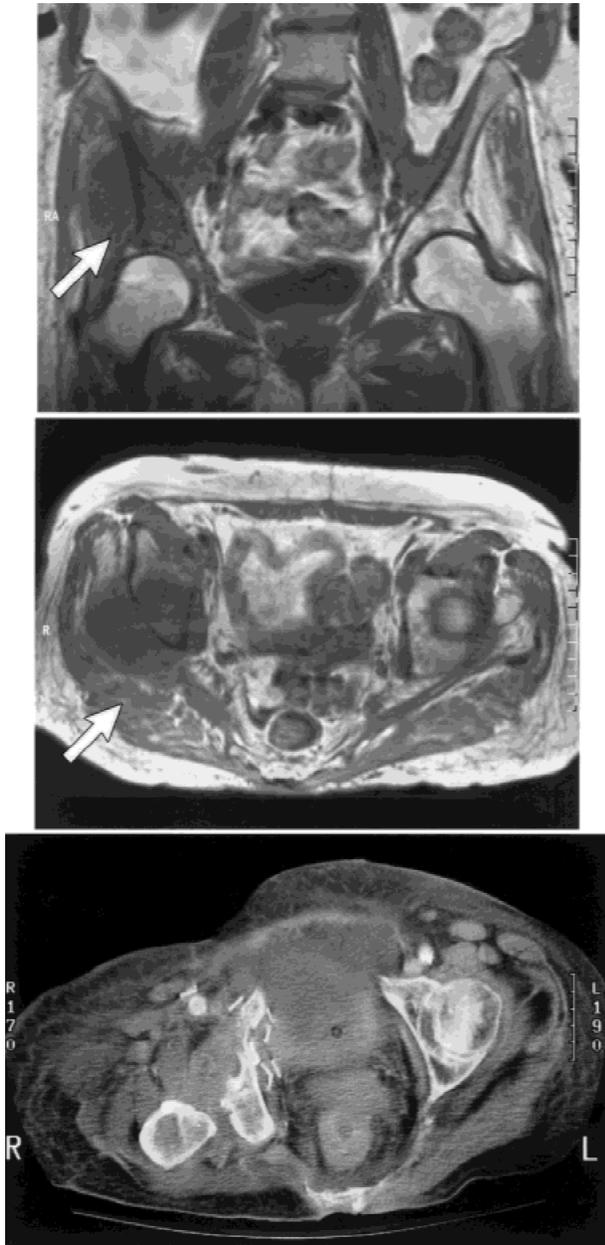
Case Study #2: presurgical magnetic resonance imaging (Figure 2A and 2B) and postsurgical computerized tomography (Figure 2C). Figures 2A (top) and 2B (middle) show a sarcoma arising from the right innominate bone with a soft tissue mass that displaces the gluteus muscles. Figure 2C (bottom) demonstrates evidence of a right hemipelvectomy with extensive edema throughout the soft tissues.
